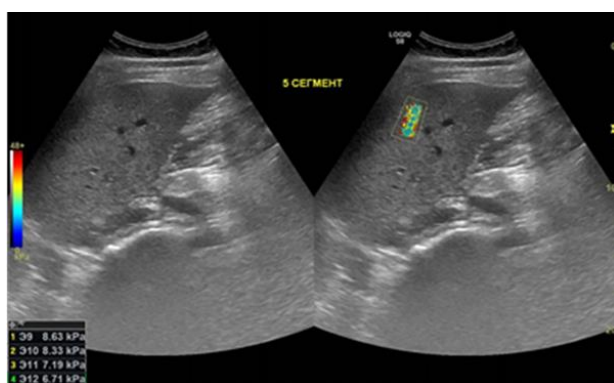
Ultrasound images of the liver parenchyma in stage F2: 2D (left) and 2D SWE (right) modes. In the lower left corner, the average values of 2SWE are 7.6 kPa, the speed of 2D SWE is 1.7 m/s.
